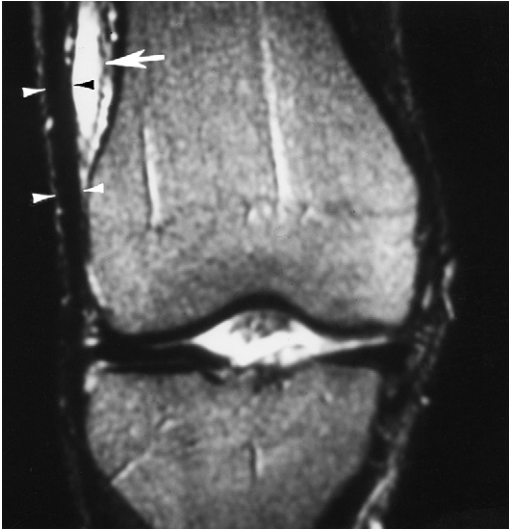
Iliotibial band friction syndrome. Coronal T2-weighted image shows a fluid collection between the iliotibial band and the femur (arrow). Also, the iliotibial band is thickened markedly (arrowheads).
